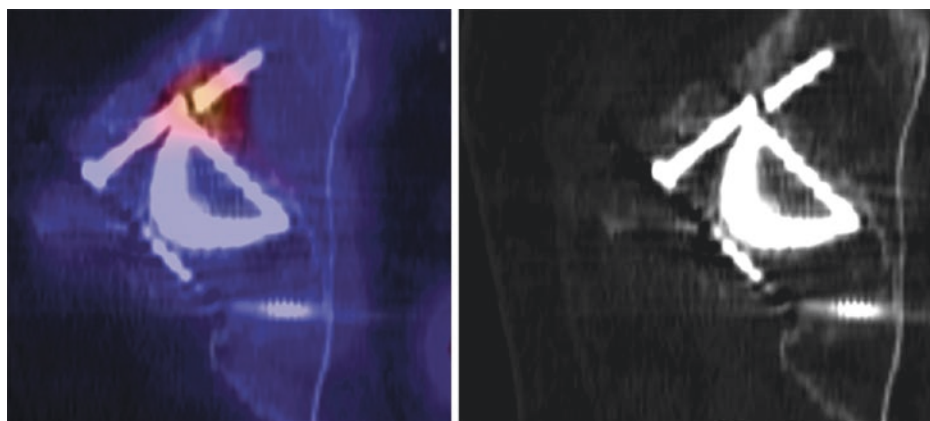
Bone scintigraphy in a patient previously submitted to right hip prosthesis. Broken screw and enhanced tracer uptake in the upper acetabulum indicate loosening of a cup of the endoprosthesis as visualized on fused SPECT/CT image (left panel) and on low-dose CT image (right panel)
